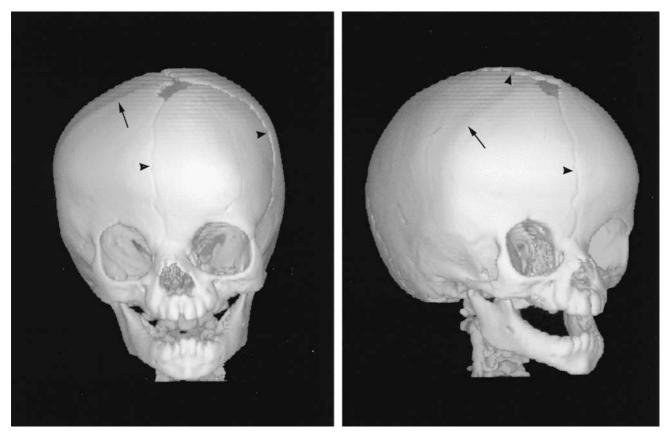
Anteroposterior and right oblique three-dimensional CT reconstruction of the proband's skull at the age of nine months, demonstrating synostosis of the right coronal suture. Note ridging along the line of the involved suture (arrow). The metopic, sagittal and left coronal sutures are patent (arrowheads).
